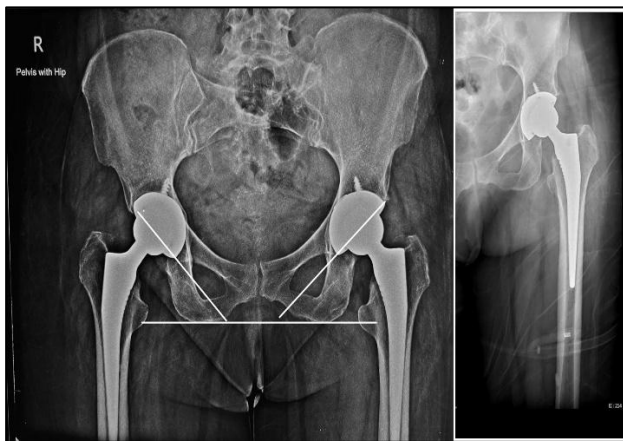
Postoperative radiograph of a showing bilateral (panel A) and unilateral THA (panel B) with Latitud total hip replacement system.
